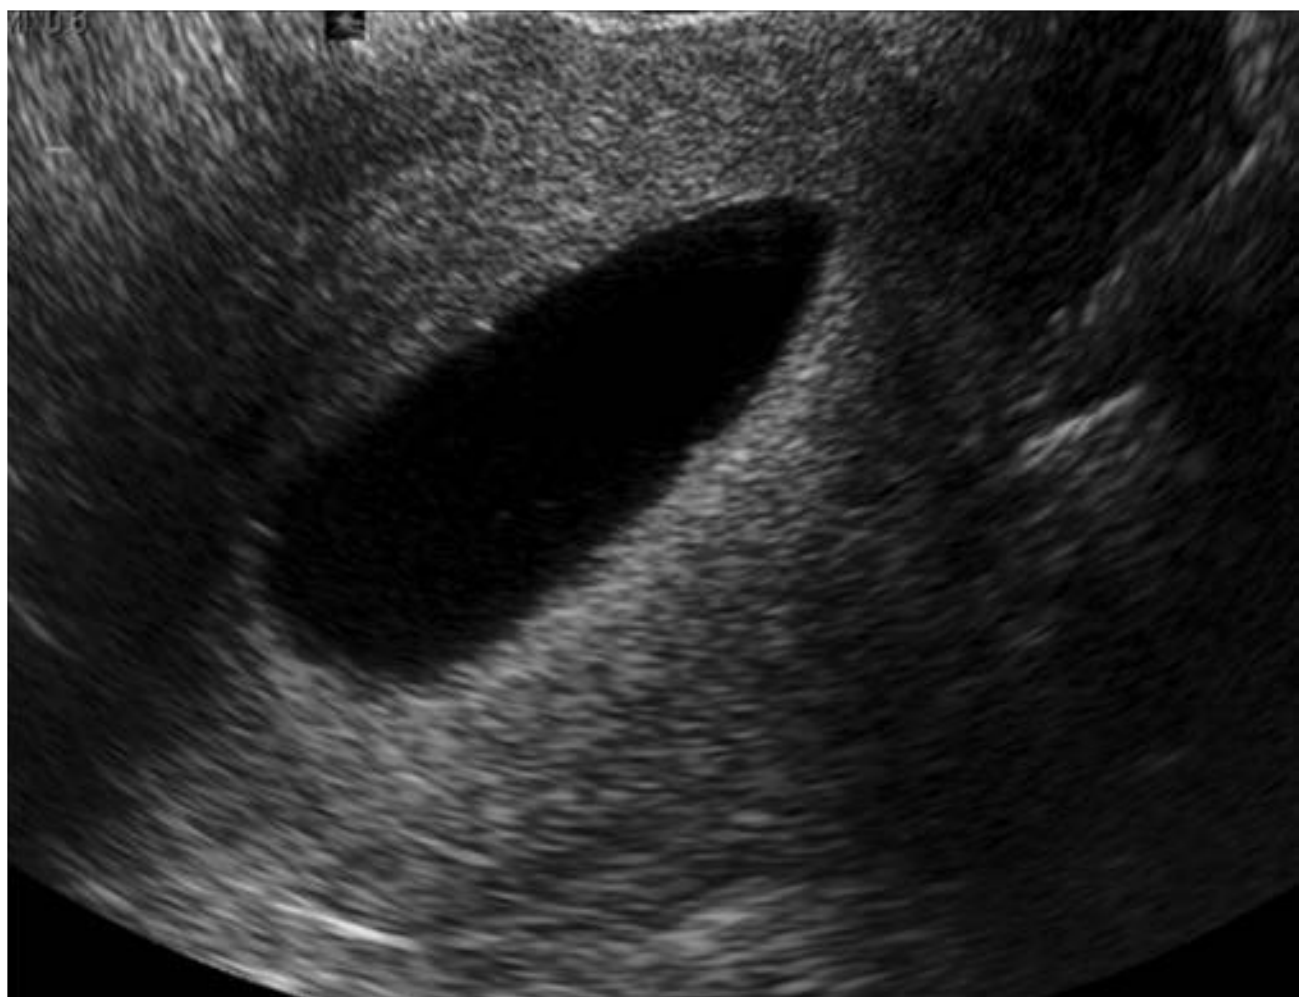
Saline infusion sonography of a normal endometrial cavity.
